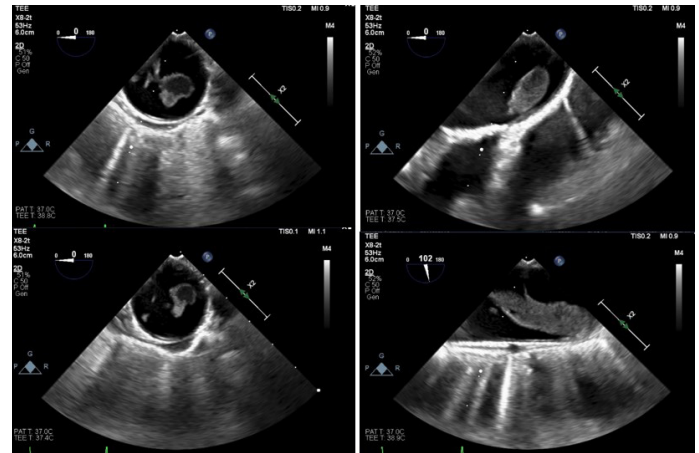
Intra-operative Transesophageal Echocardiogram showing thrombus.
